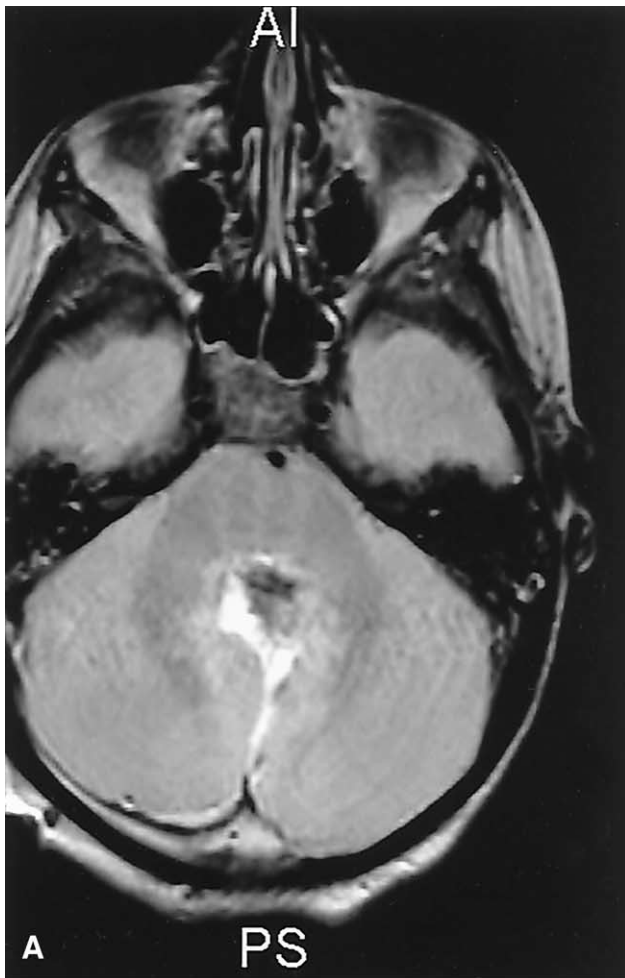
(A) Axial T_2 -weighted magnetic resonance imaging (TR 2600 ms, TE 90 ms). Postoperative changes are observed in the midline vermian region. (B) Axial diffusion-weighted magnetic resonance imaging (TR 10,000 ms, TE 97 ms). No evidence of ischemic injury. AI = anterior inferior, PS = posterior superior.
